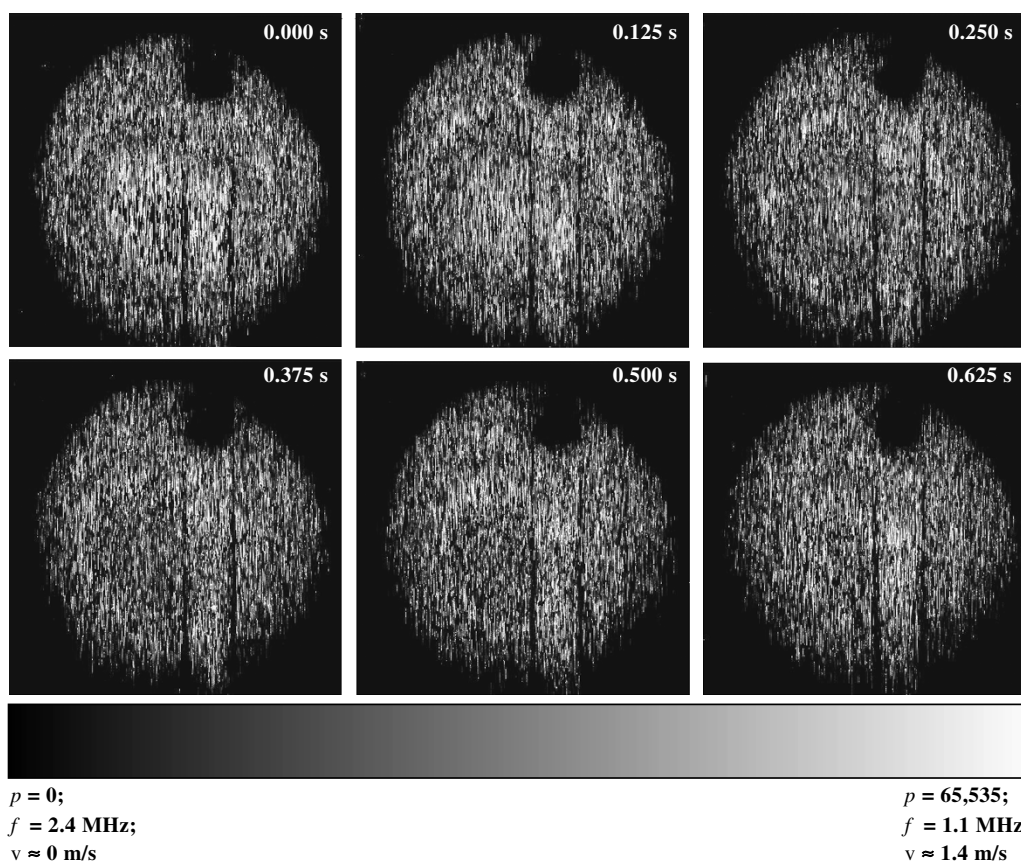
Real-time Doppler OCT of fluid flow. A sequence of six images was acquired during a fluid flow transient caused by turning off the syringe pump. Two sets of rings can be observed in the first image. The rings collapse during the reduction in fluid flow velocity. The time is indicated in each image. The gray-scale bar indicates the pixel values (p), the instantaneous frequency (f), and the fluid flow velocity (v), corresponding to the respective intensity in the images.
